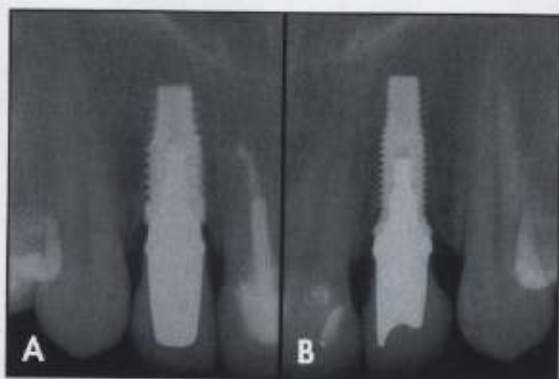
Postoperative view of implant in site #7. 17B. Periapical view confirming implant placement in site #10.
